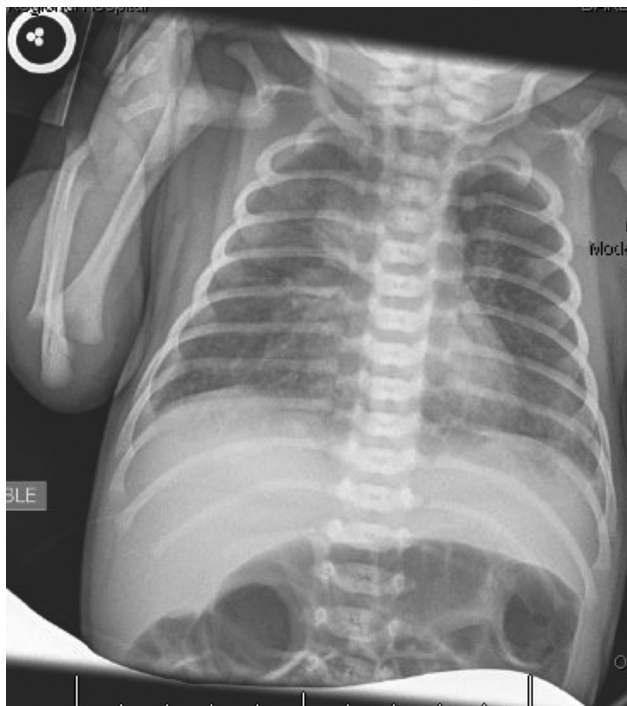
Infant chest radiograph at 8 hours demonstrating multiple pulmonary opacities.
